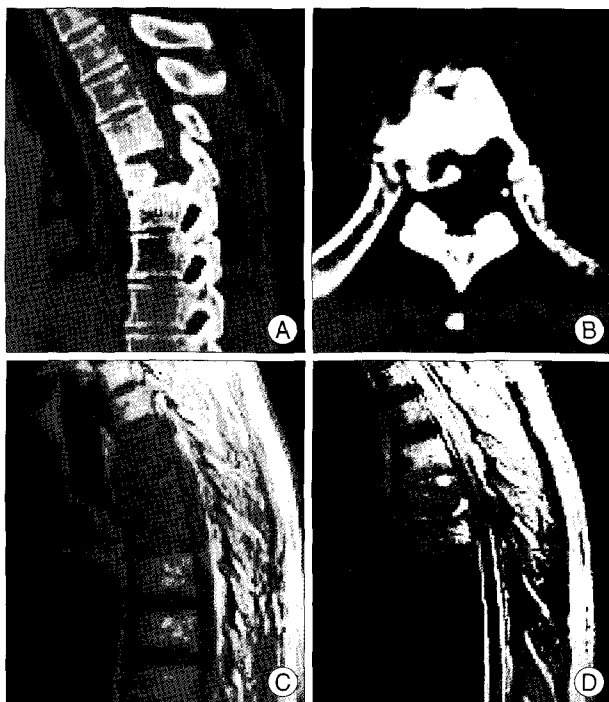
Radiological studies reveal significant abnormality at T5 level. A and B : Computed tomographic scans show high density at T4, T5 and T6 level and osteolytic lesion at T5 level. C and D : Sagittal magnetic resonance images reveal hypointense T1-weighted image and hyperintense T2-weighted image at T4, T5 and T6 body with the compression of the subarachnoid space.
